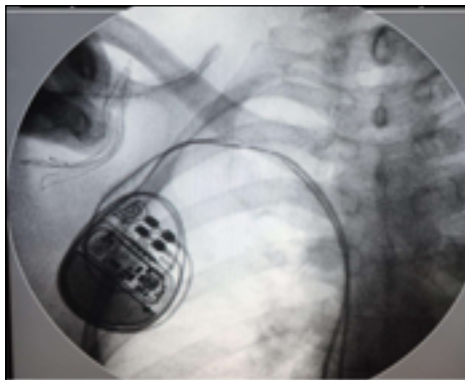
Chest radiograph demonstrating complete fracture of the atrial lead.
